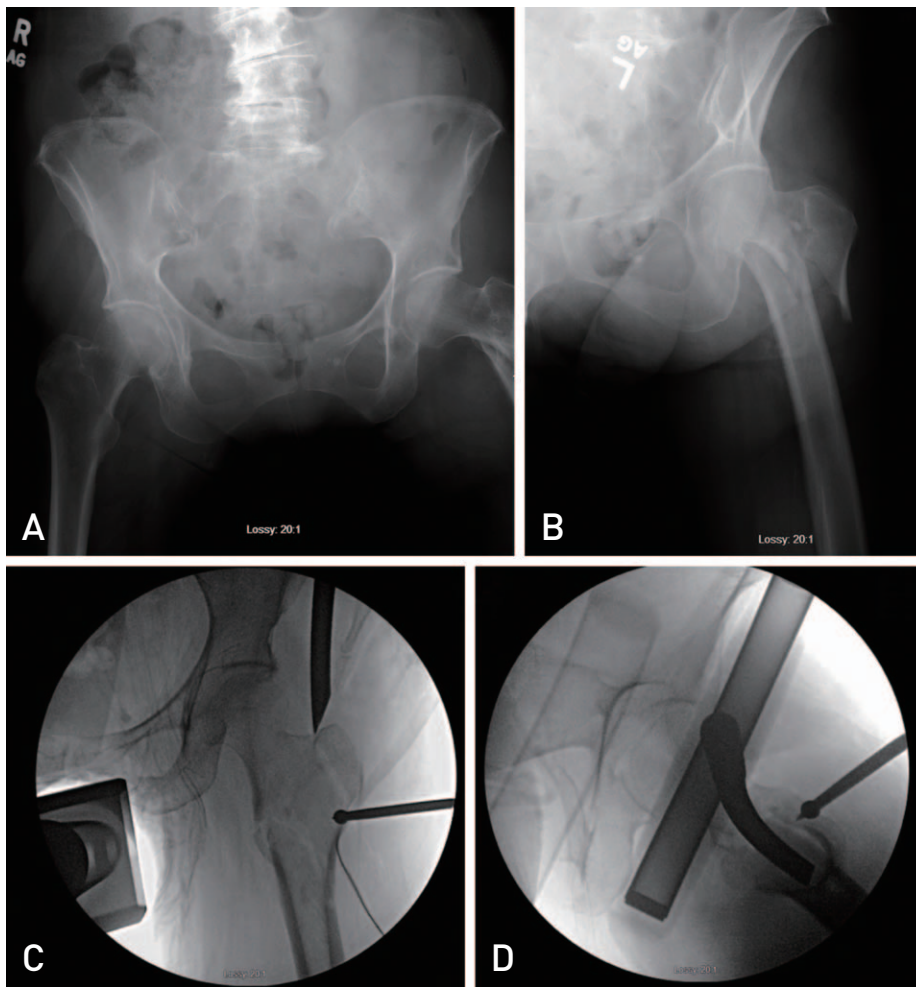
Anteroposterior radiograph of the pelvis (A) and left hip (B) demonstrating an intertrochanteric fracture with a reverse obliquity pattern. Anteroposterior (C) and lateral (D) intraoperative fluoroscopic imaging showing the use of a reduction tool.
